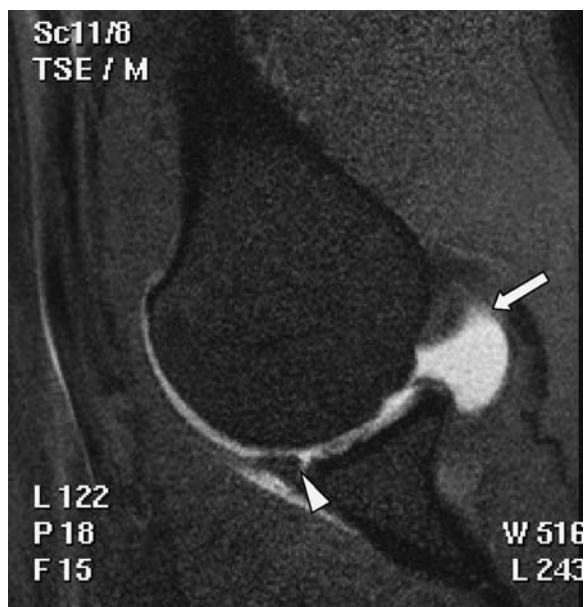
Antero-inferior labral tear with intact spinatus tendons. T1-weighted fat-saturated MR arthrogram in ABER view. Articular undersurface of supraspinatus tendon is completely normal (arrow). Inferior glenohumeral ligament is under stress in this view accentuating subtle antero-inferior labral tear (arrowhead)
